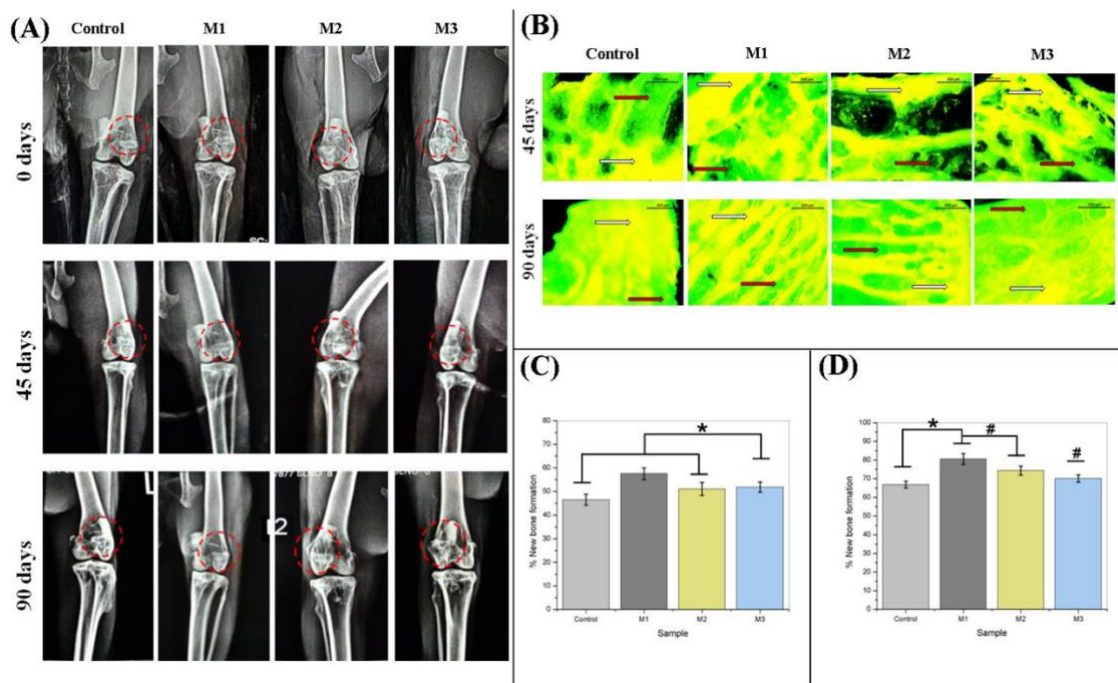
(A) Radiographic images of the implanted bones after '0', 45 and 90 days. The red broken circles are highlighting the area of defect and implant; (B) Fluorochrome labeling images of implanted bone taken after 45 and 90 days; Golden yellow (white arrow) represents new bone and sea green (red arrow) represents old bone. Scale bar: 500 μm ; Percentage of new bone formation after (C) 45 and (D) 90 days. Data: Mean \pm SD, [n=4]. Reproduced with permission from Lalzawmliana et al. 2019⁴⁸. Copyright © 2018, Elsevier.
